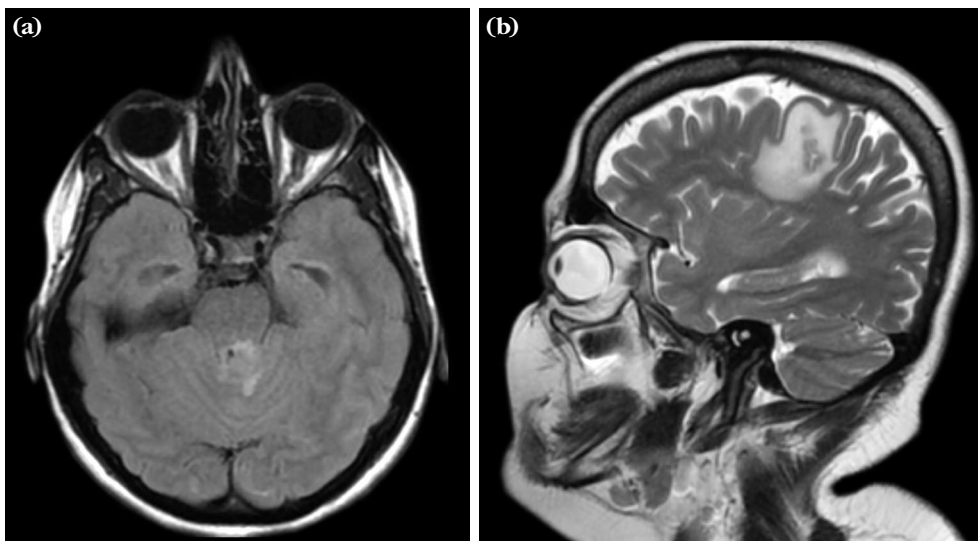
(a) Hyperintensity in the left lateral neighborhood of the fourth ventricle in the axial FLAIR sequence (Case 1). (b) Right parietal infiltrative lesion detected on cranial MRI (Case 2). FLAIR: Fluid-attenuated inversion recovery; MRI: Magnetic resonance imaging.
